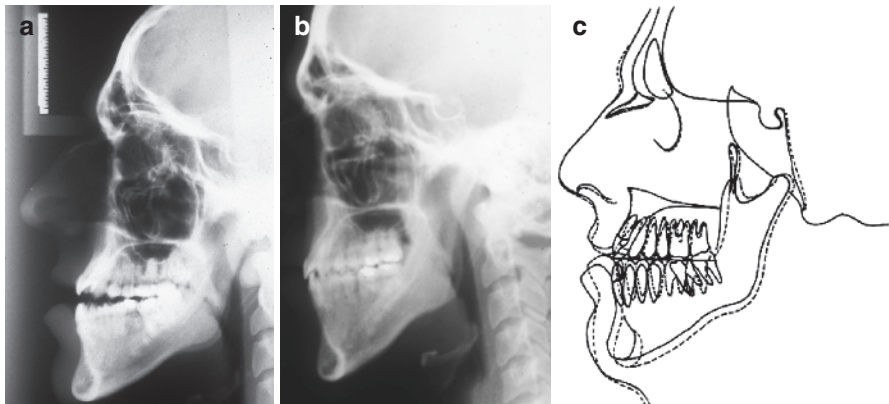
Cephalometric radiographs. (a) Pretreatment. (b) Posttreatment. (c) Pre-/posttreatment superimposition
